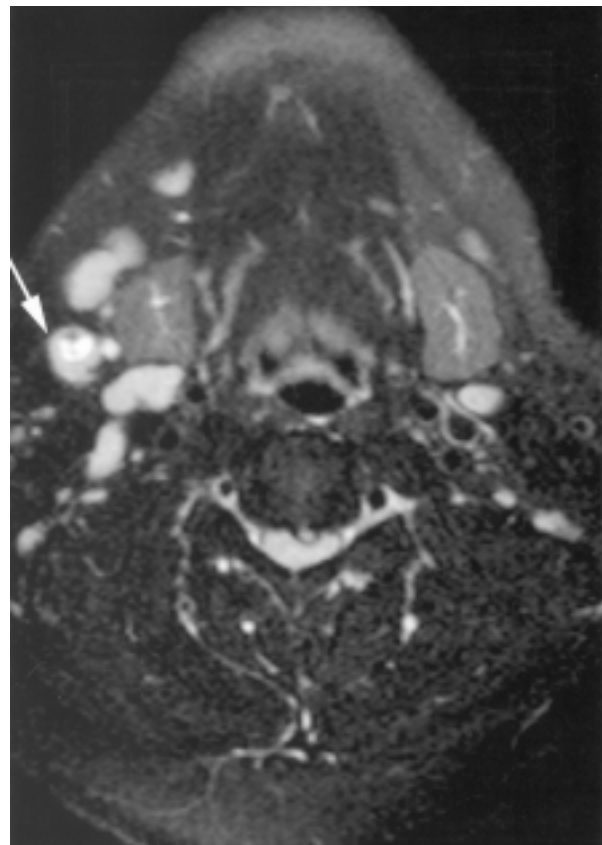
Neck metastasis presenting as central necrosis in a small node. The T2-weighted MRI shows mixed high and intermediate signal intensities in the central portion of the right non-enlarged submandibular node (arrow).
